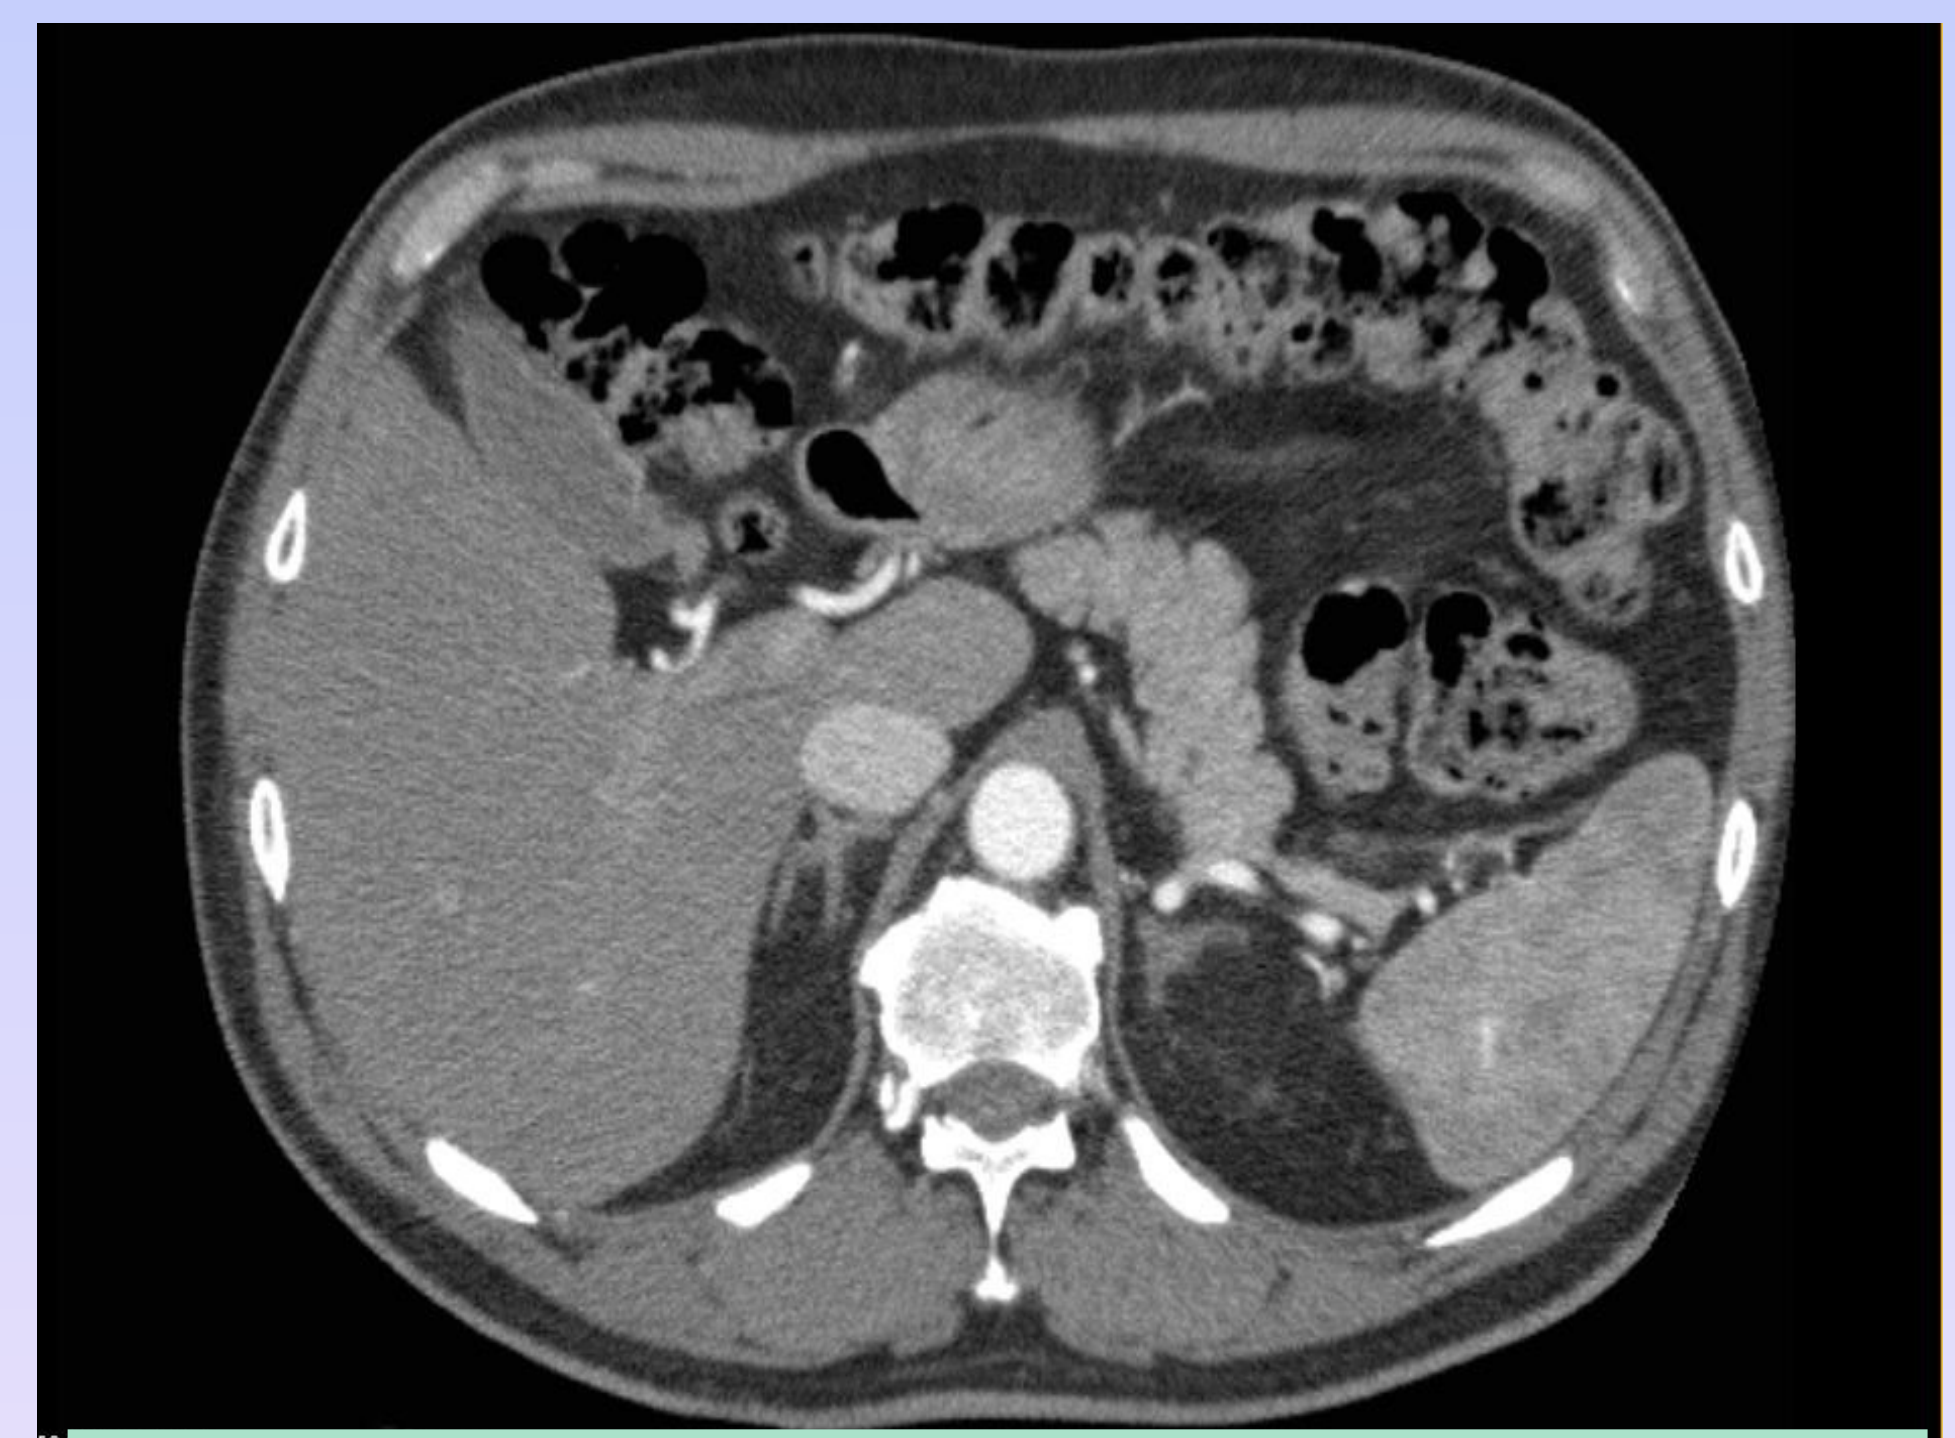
Abdominal CT scan with contrast
